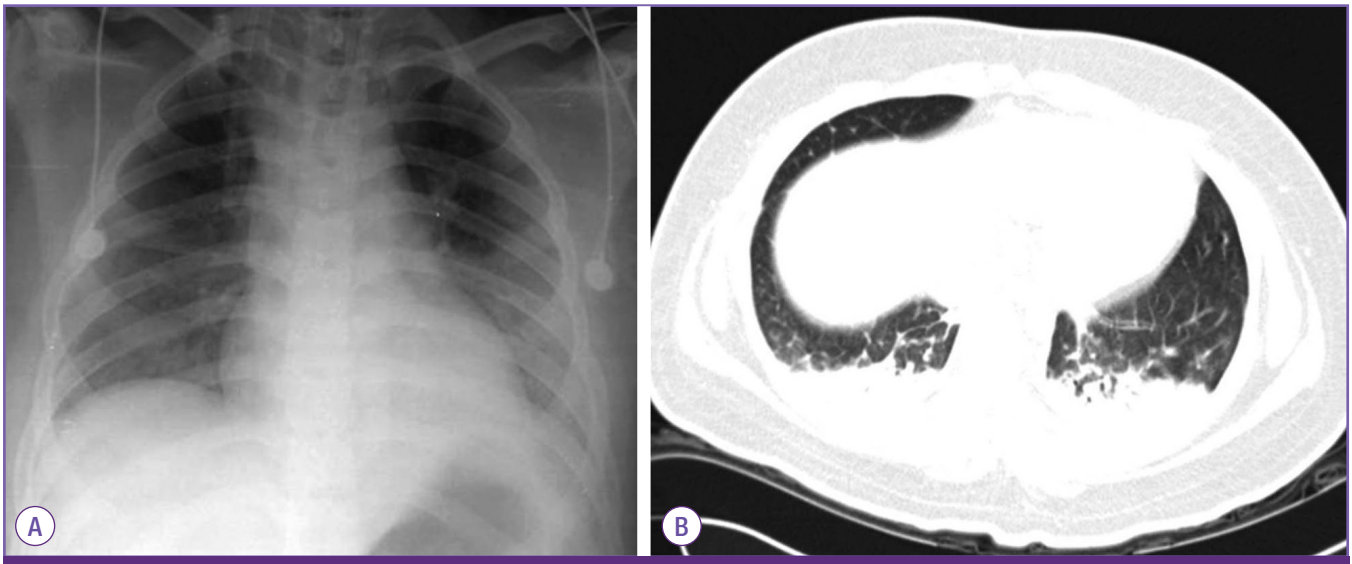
Chest radiograph on the fourth hospital day showing bilateral lower lobe infiltrates (A). Chest computed tomography images on the third hospital day shows bilateral and symmetric compartmental consolidation in gravity-dependent areas of the lung compatible with acute respiratory distress syndrome (B).
